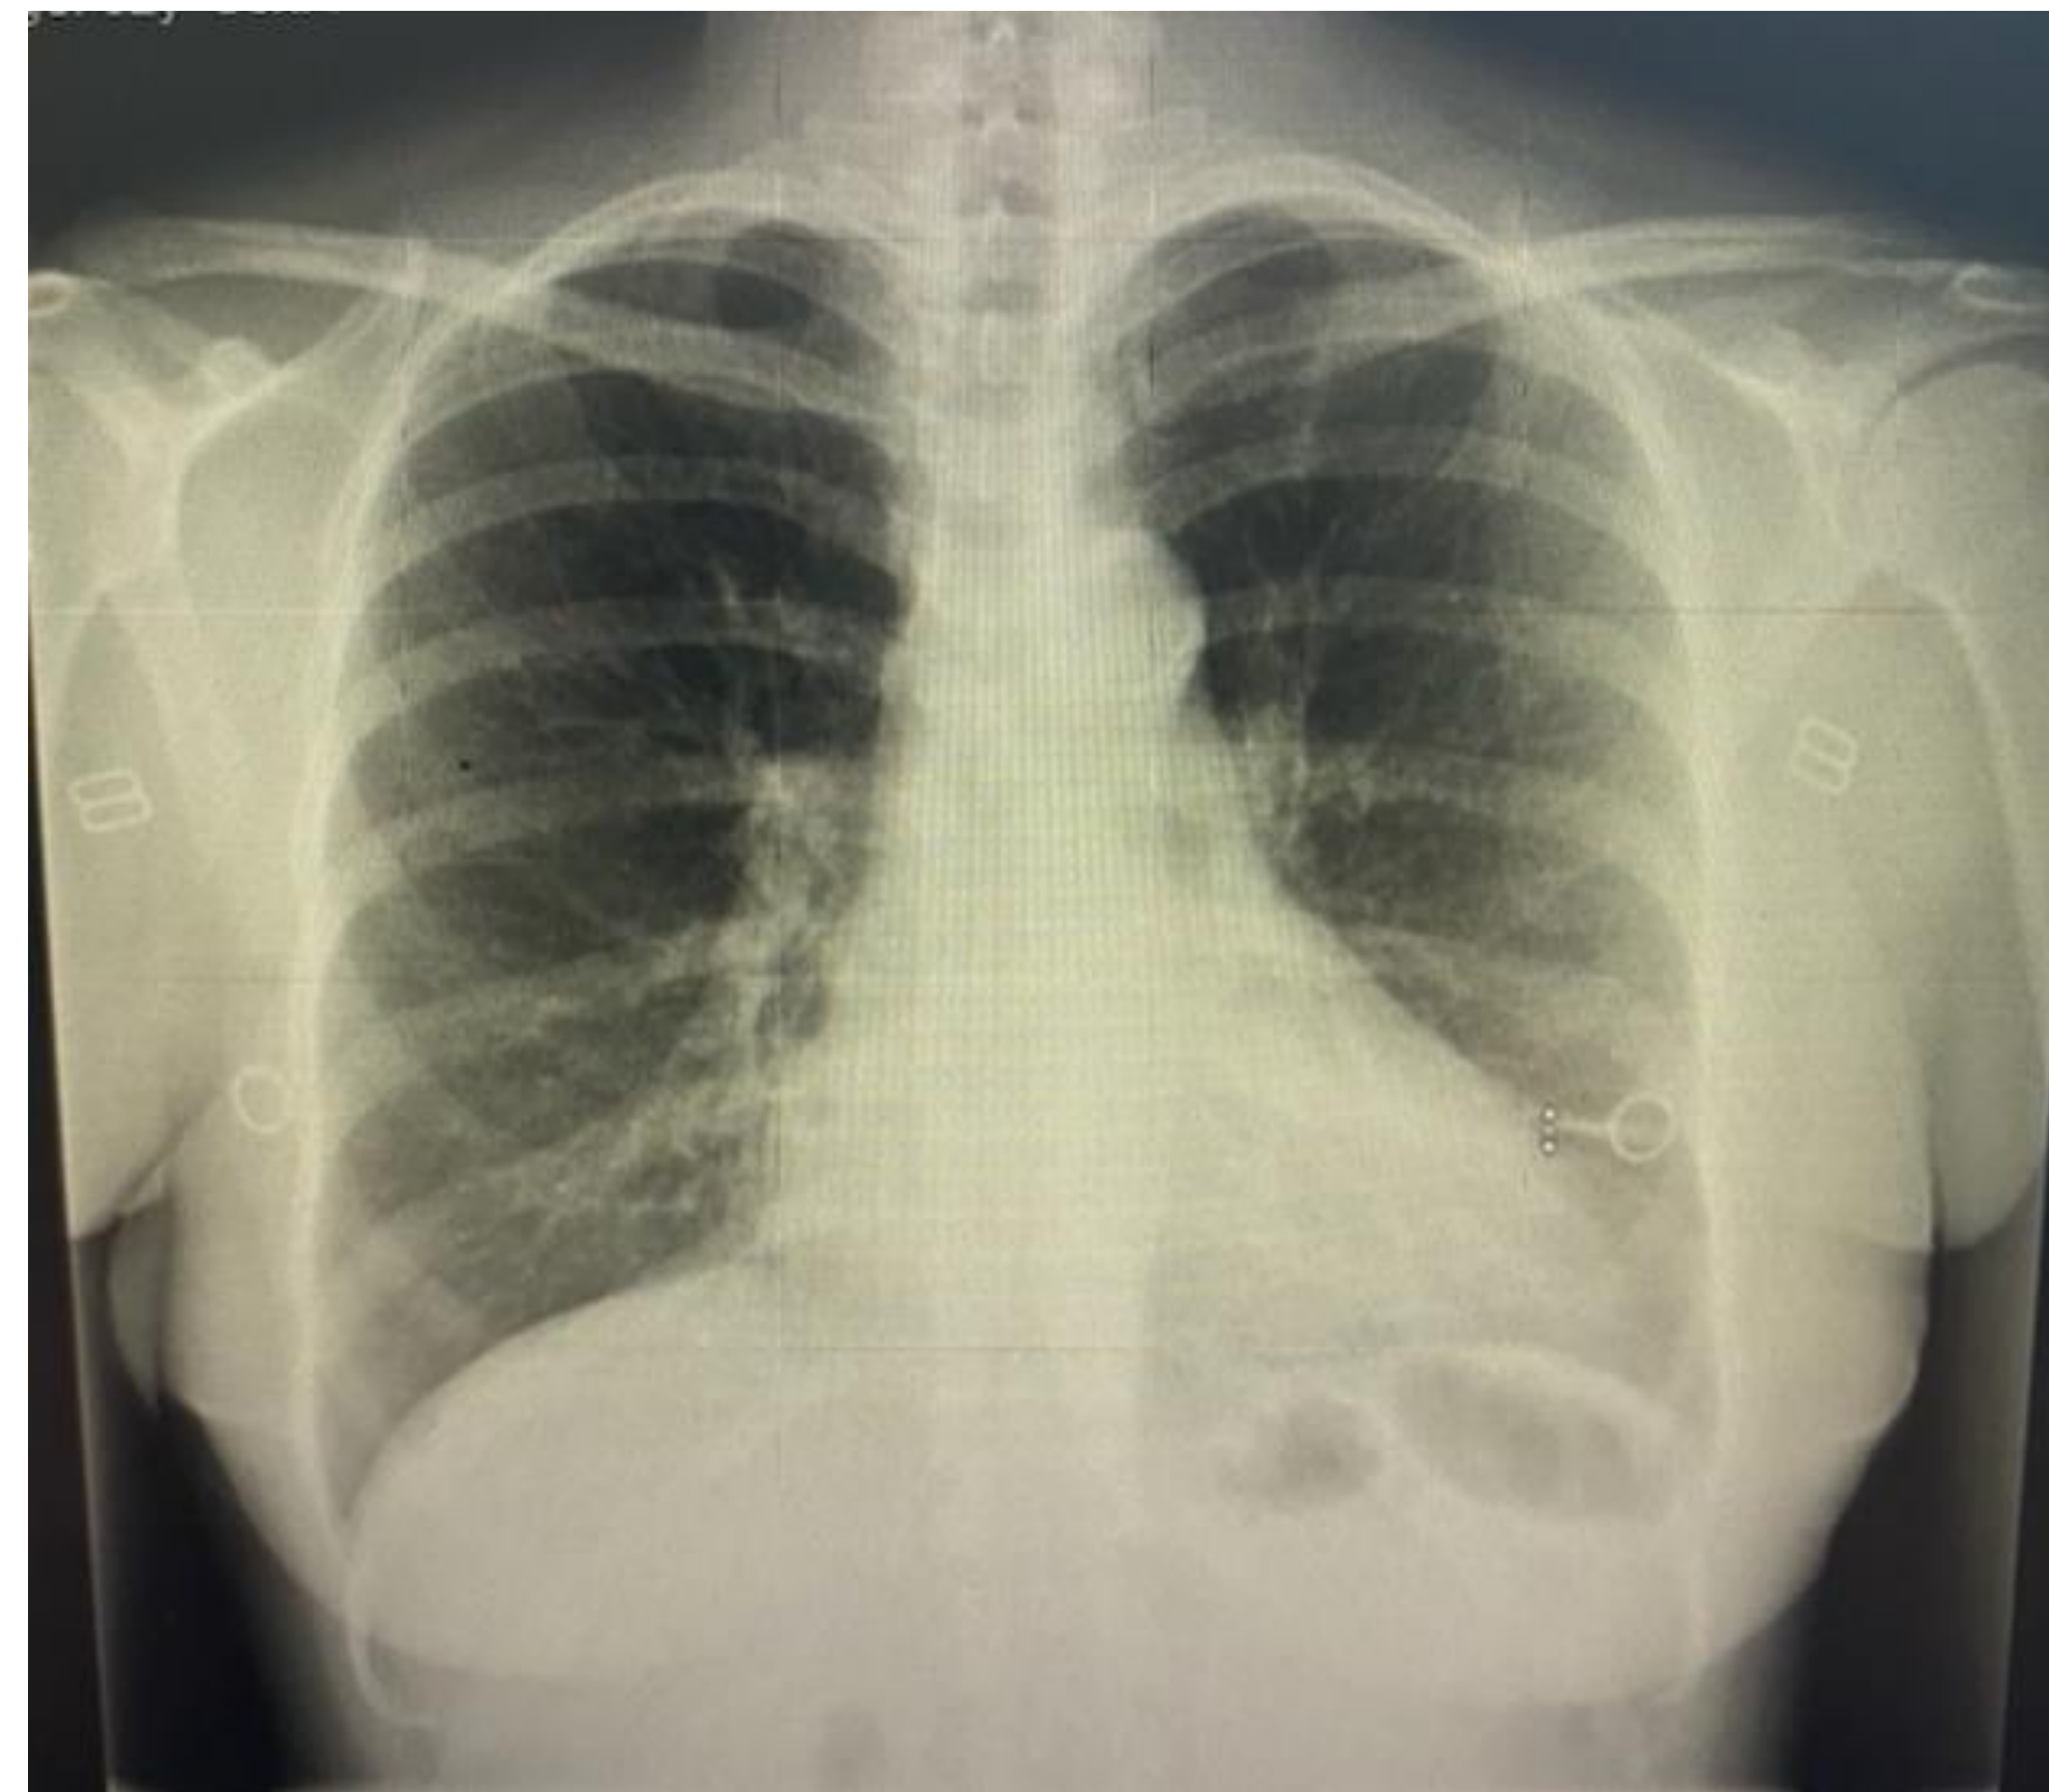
Chest X-ray showing mild prominence of the cardiac silhouette
